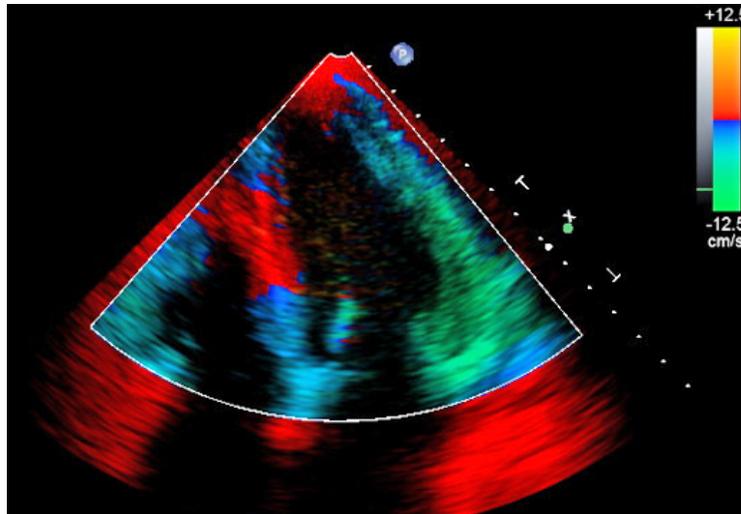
Doppler tissue image from the heart.
